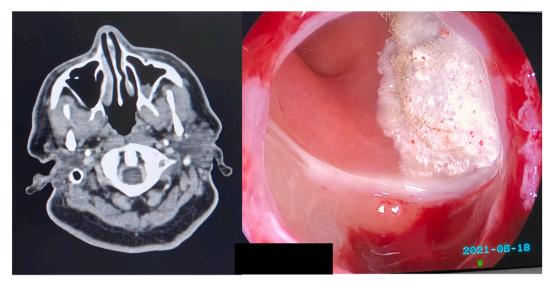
Fig. 6A) CT Brain axial section showing left Maxillary sinus mucosal thickening due to mucormycosis. Fig. 6B) Nasoendoscopic picture of the same patient with a fungal ball in the left maxillary sinus.
